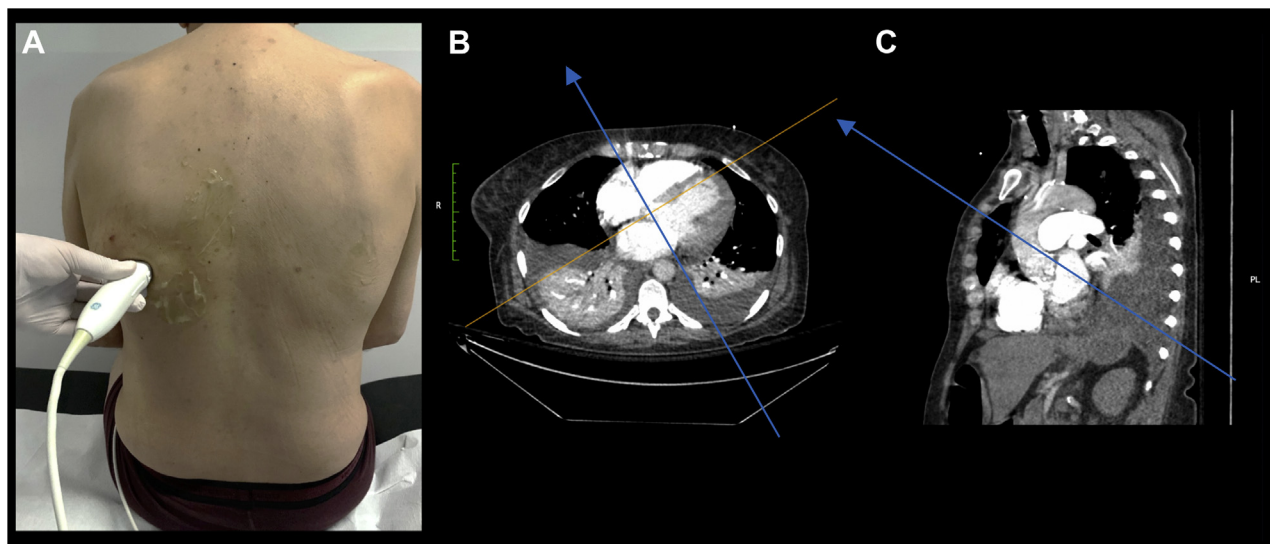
Posterior thoracic window image acquisition: (A) positioning of the transducer in the left subscapular region with the side marker pointing to the right shoulder; then the ultrasound beam is directed (B) medially (blue line) and (C) cranially as shown in the computed tomography scan images from the same patient.
